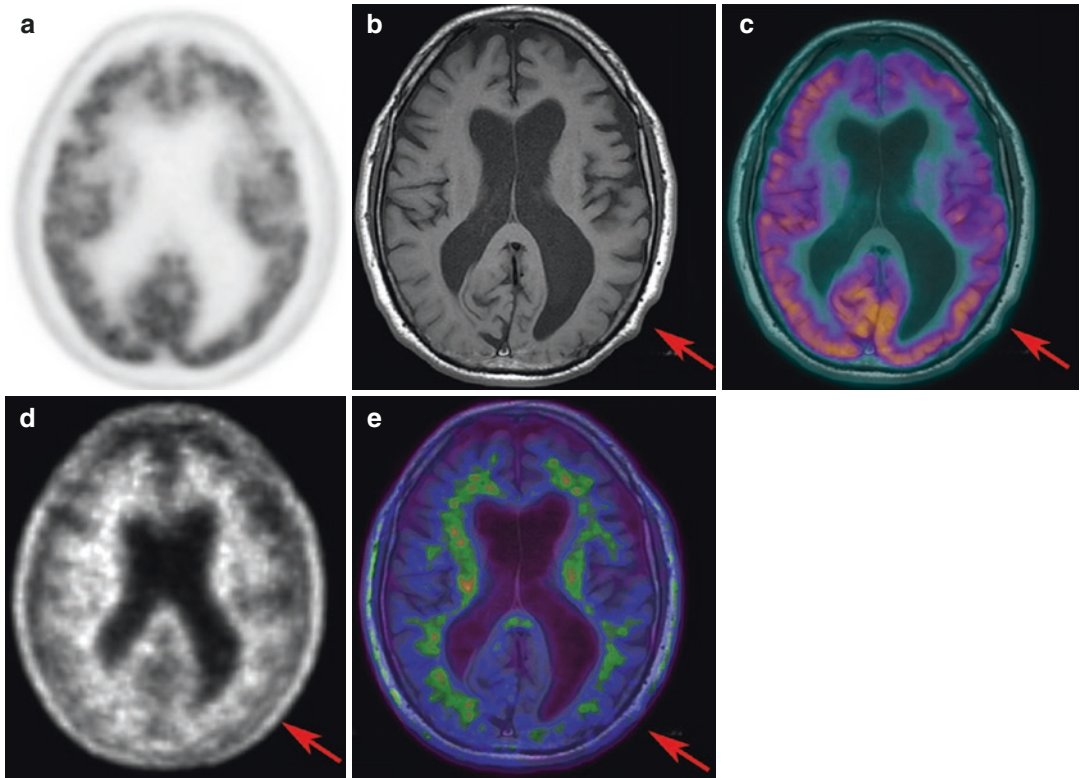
Axial ^{18}F -FDG PET scan in (a) in a subject with clinical suspect of frontotemporal dementia. In (b) we report the axial MR images showing a significant cortical atrophy involving in particular the left temporal lobe (arrow); in (c), ^{18}F -FDG PET/MR fusion imaging showing a significant reduction of brain glucose consumption in the left frontal lobe and a mild decrease of glucose consumption in the left temporal lobe. In (d) we report an axial image of ^{18}F -florbetaben PET scan showing no significant amyloid burden in brain. Nevertheless, due to the presence of cortical atrophy, interpretation of PET scan is doubtful in the temporal lobe (arrow). ^{18}F -Florbetaben PET/MR fusion imaging in (e) shows no significant amyloid burden in the left temporal lobe
